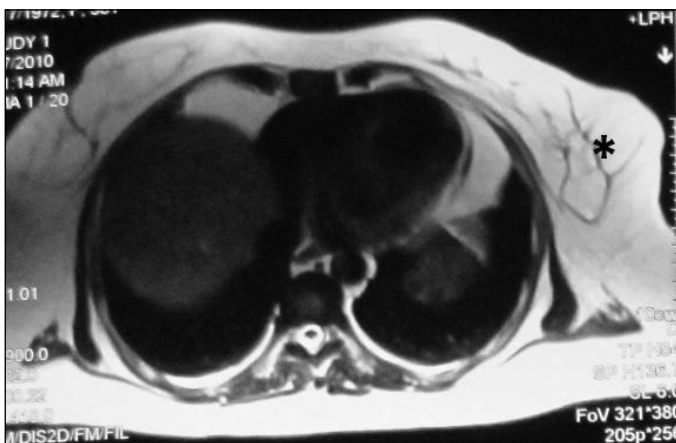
Contrast enhanced computed tomography scan of upper abdomen (A), and chest (B) showing left axillary lymphadenopathy (star).
